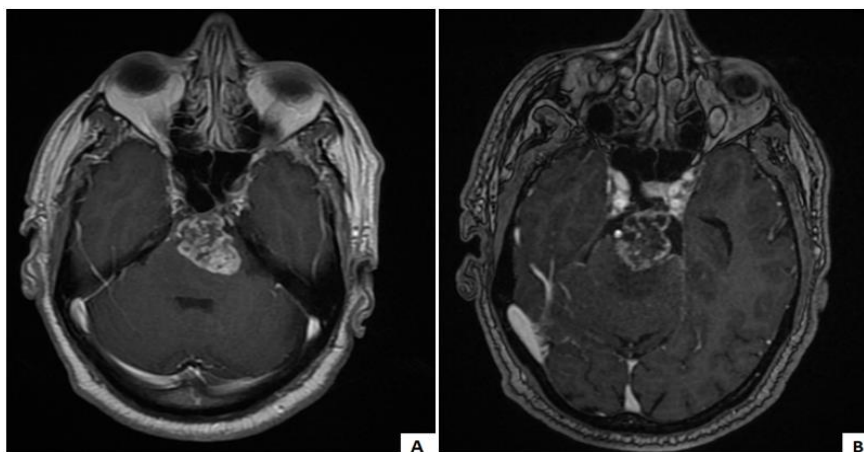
MRI T1 sequence after Gadolinium injection showing an important heterogeneous enhancement of the mass. Axial T1 Spin Echo Gado + (B) Axial T1 Gradient Echo Gado +
